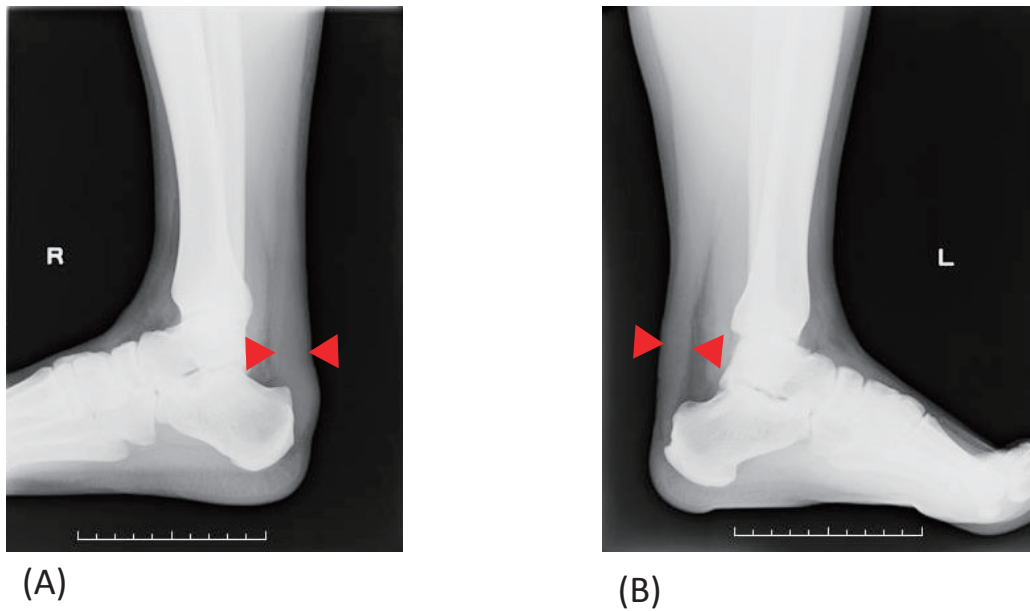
Achilles tendon radiography in patients with FH
